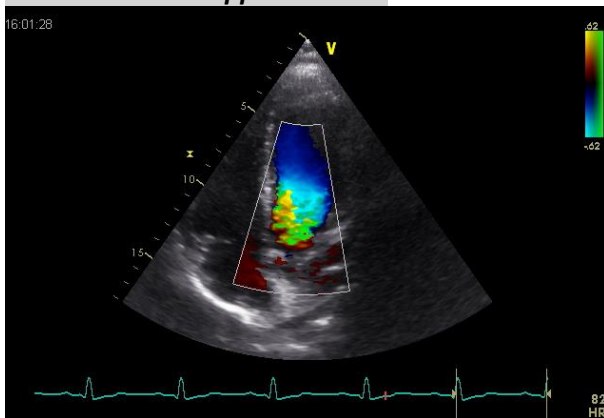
Color Doppler LVOT
